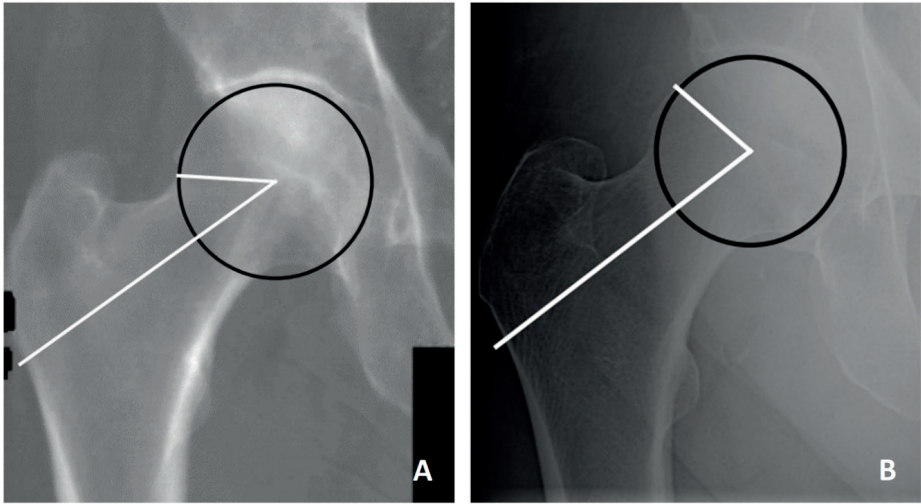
This is an example of how a slight difference in circle fit can result in a large difference in the measured alpha angle (AA). A: AA as determined on the right hip DXA image. B: AA as determined on the pelvic radiograph.
